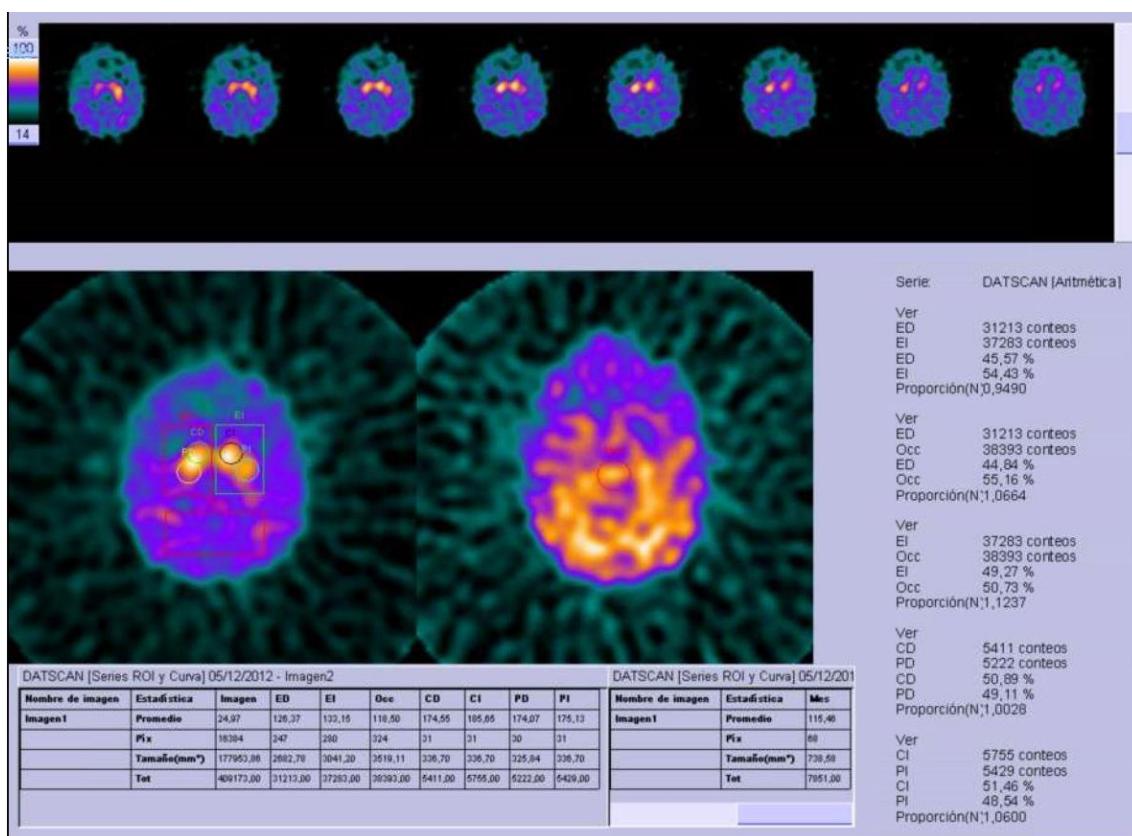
Cuantificación SPECT [¹²³I]-loflupano en paciente con AMS-P.
